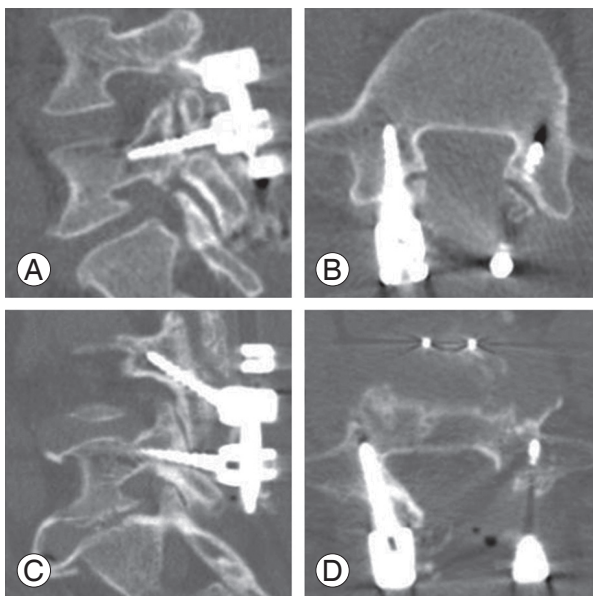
Postoperative computed tomography demonstrating typical screw insertion in L5: sagittal view (A) and axial view (B) of L5 screws for a case with spondylolysis. Sagittal view (C) and axial view (D) for a case without spondylolysis.
